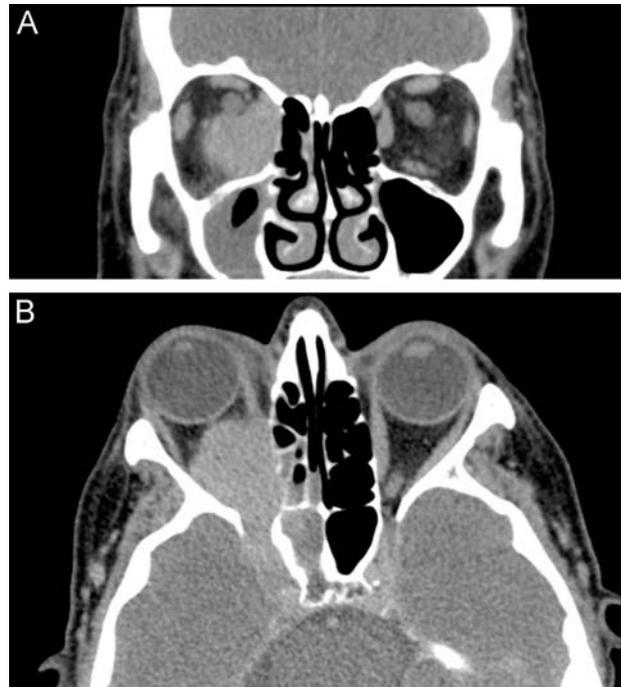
Computed tomography (CT) orbits. A, Coronal image of CT orbits demonstrating a mildly homogenous enhancing mass in the right orbit with superior displacement of the right optic nerve. B, Axial image of CT orbits demonstrating a mildly homogenous enhancing mass centred within the right superior orbital fissure with extension of the mass along the right optic foramen to the right cavernous sinus. The mass also partially abuts the right medial, lateral, and inferior rectus muscles, resulting in anterior displacement of the right globe.
